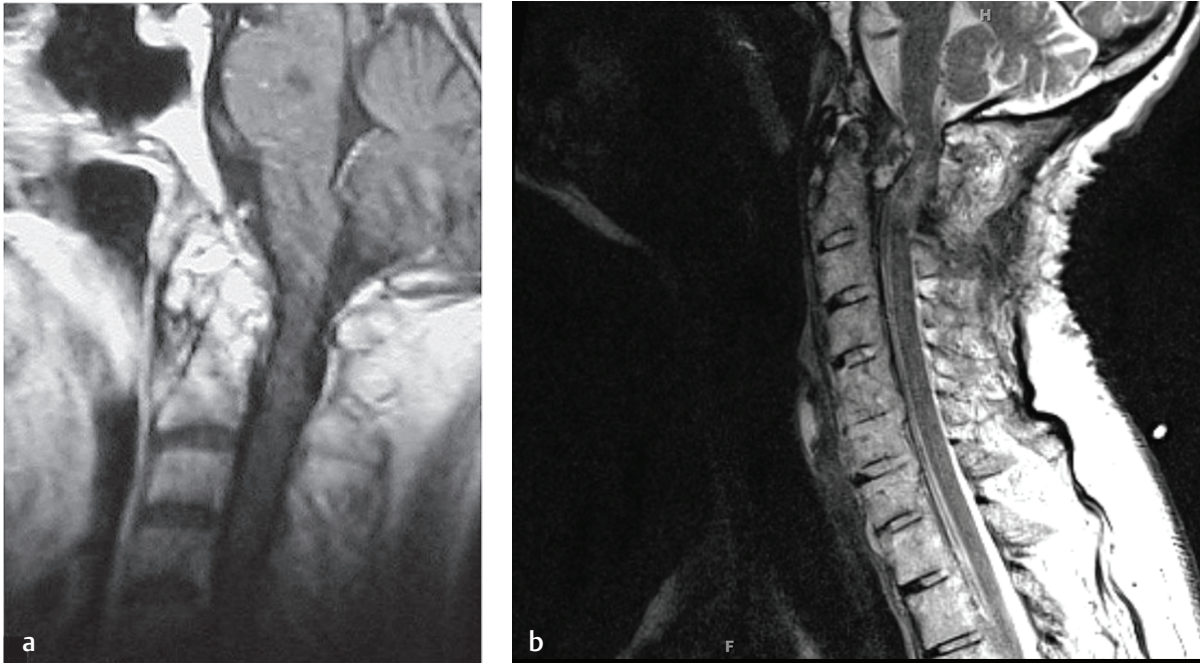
C1-C2 pannus formation. (a) A sagittal T1-weighted image shows a large pannus in the atlanto–dens interval in a patient with RA and cranial settling. (b) A sagittal T2-weighted image of a patient with a large pannus posterior to the odontoid shows it is causing cord compression.
